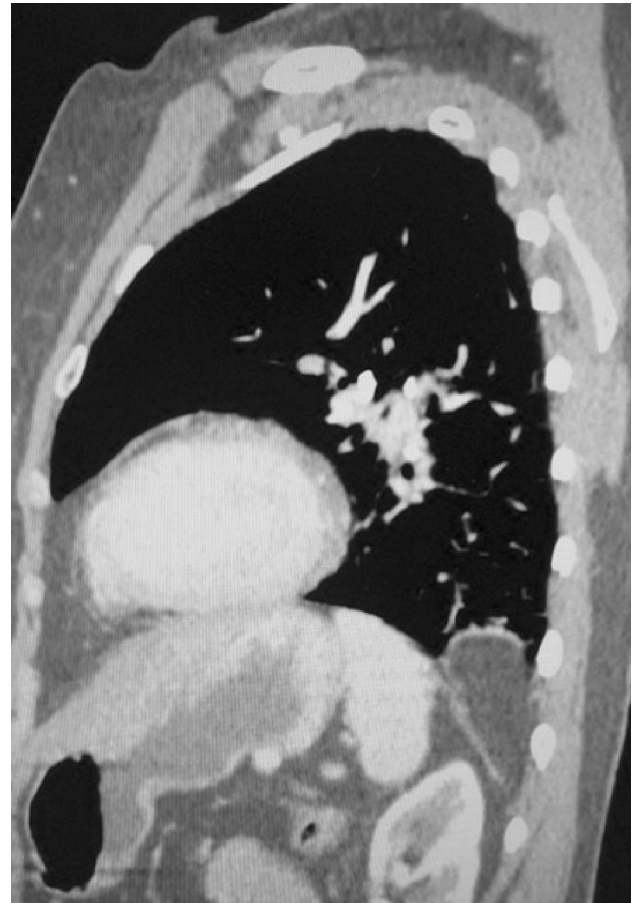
Sagittal section of CT Scan chest showing pleural lipoma with tapered margins
